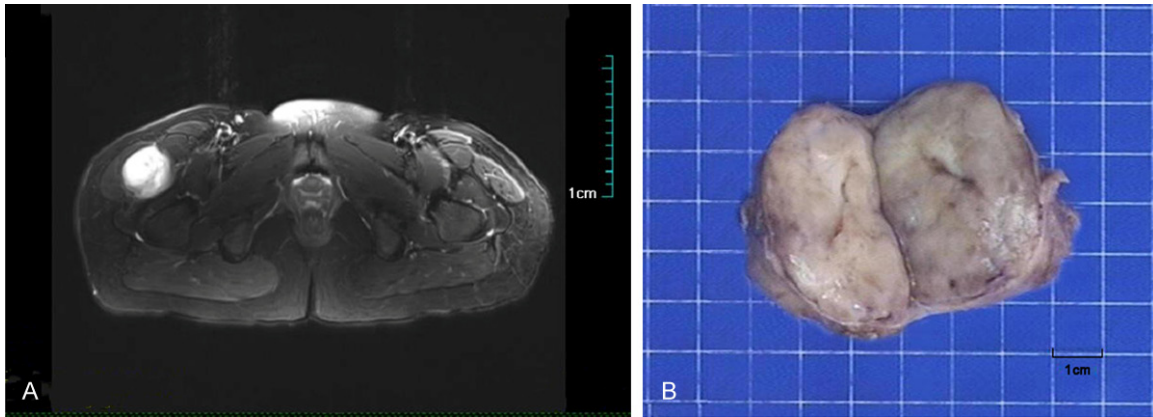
Magnetic resonance imaging (MRI) image of the hip joint and the gross of the tumor. A. The MRI showed a single mass with a clear boundary. B. The mass was ovoid and grey-white. The cut surface was revealed as smooth, glistening, and mucinous; an envelope appears to be visible on the surface of the mass.
